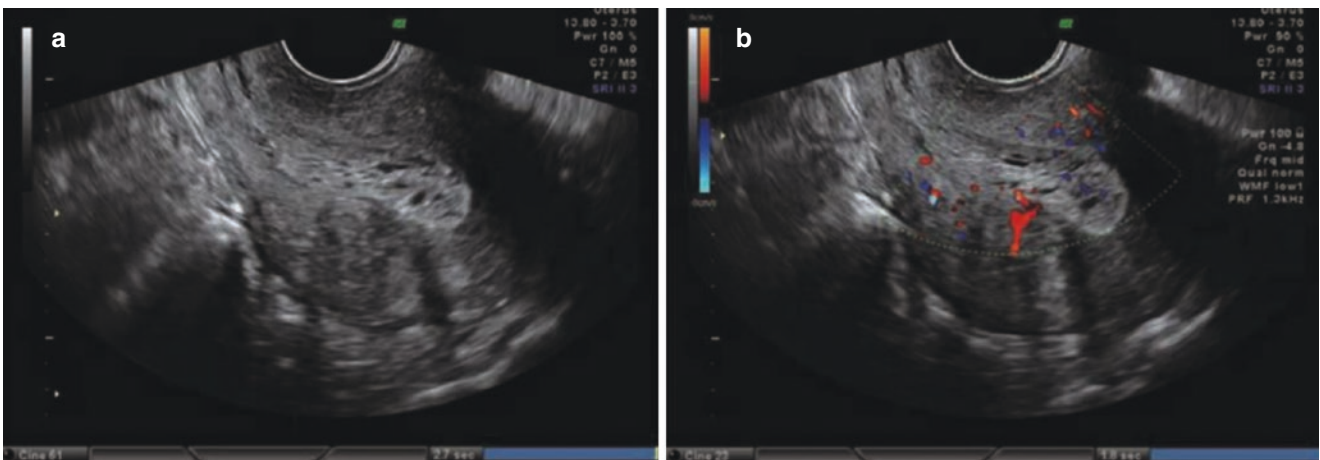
Endometrial hyperplasia. Ultrasound images show thickened endometrium with multiple small cysts (a. two-dimension, b. Color Doppler flow image). Endometrial hyperplasia is confirmed by pathological examination after diagnostic D&C
